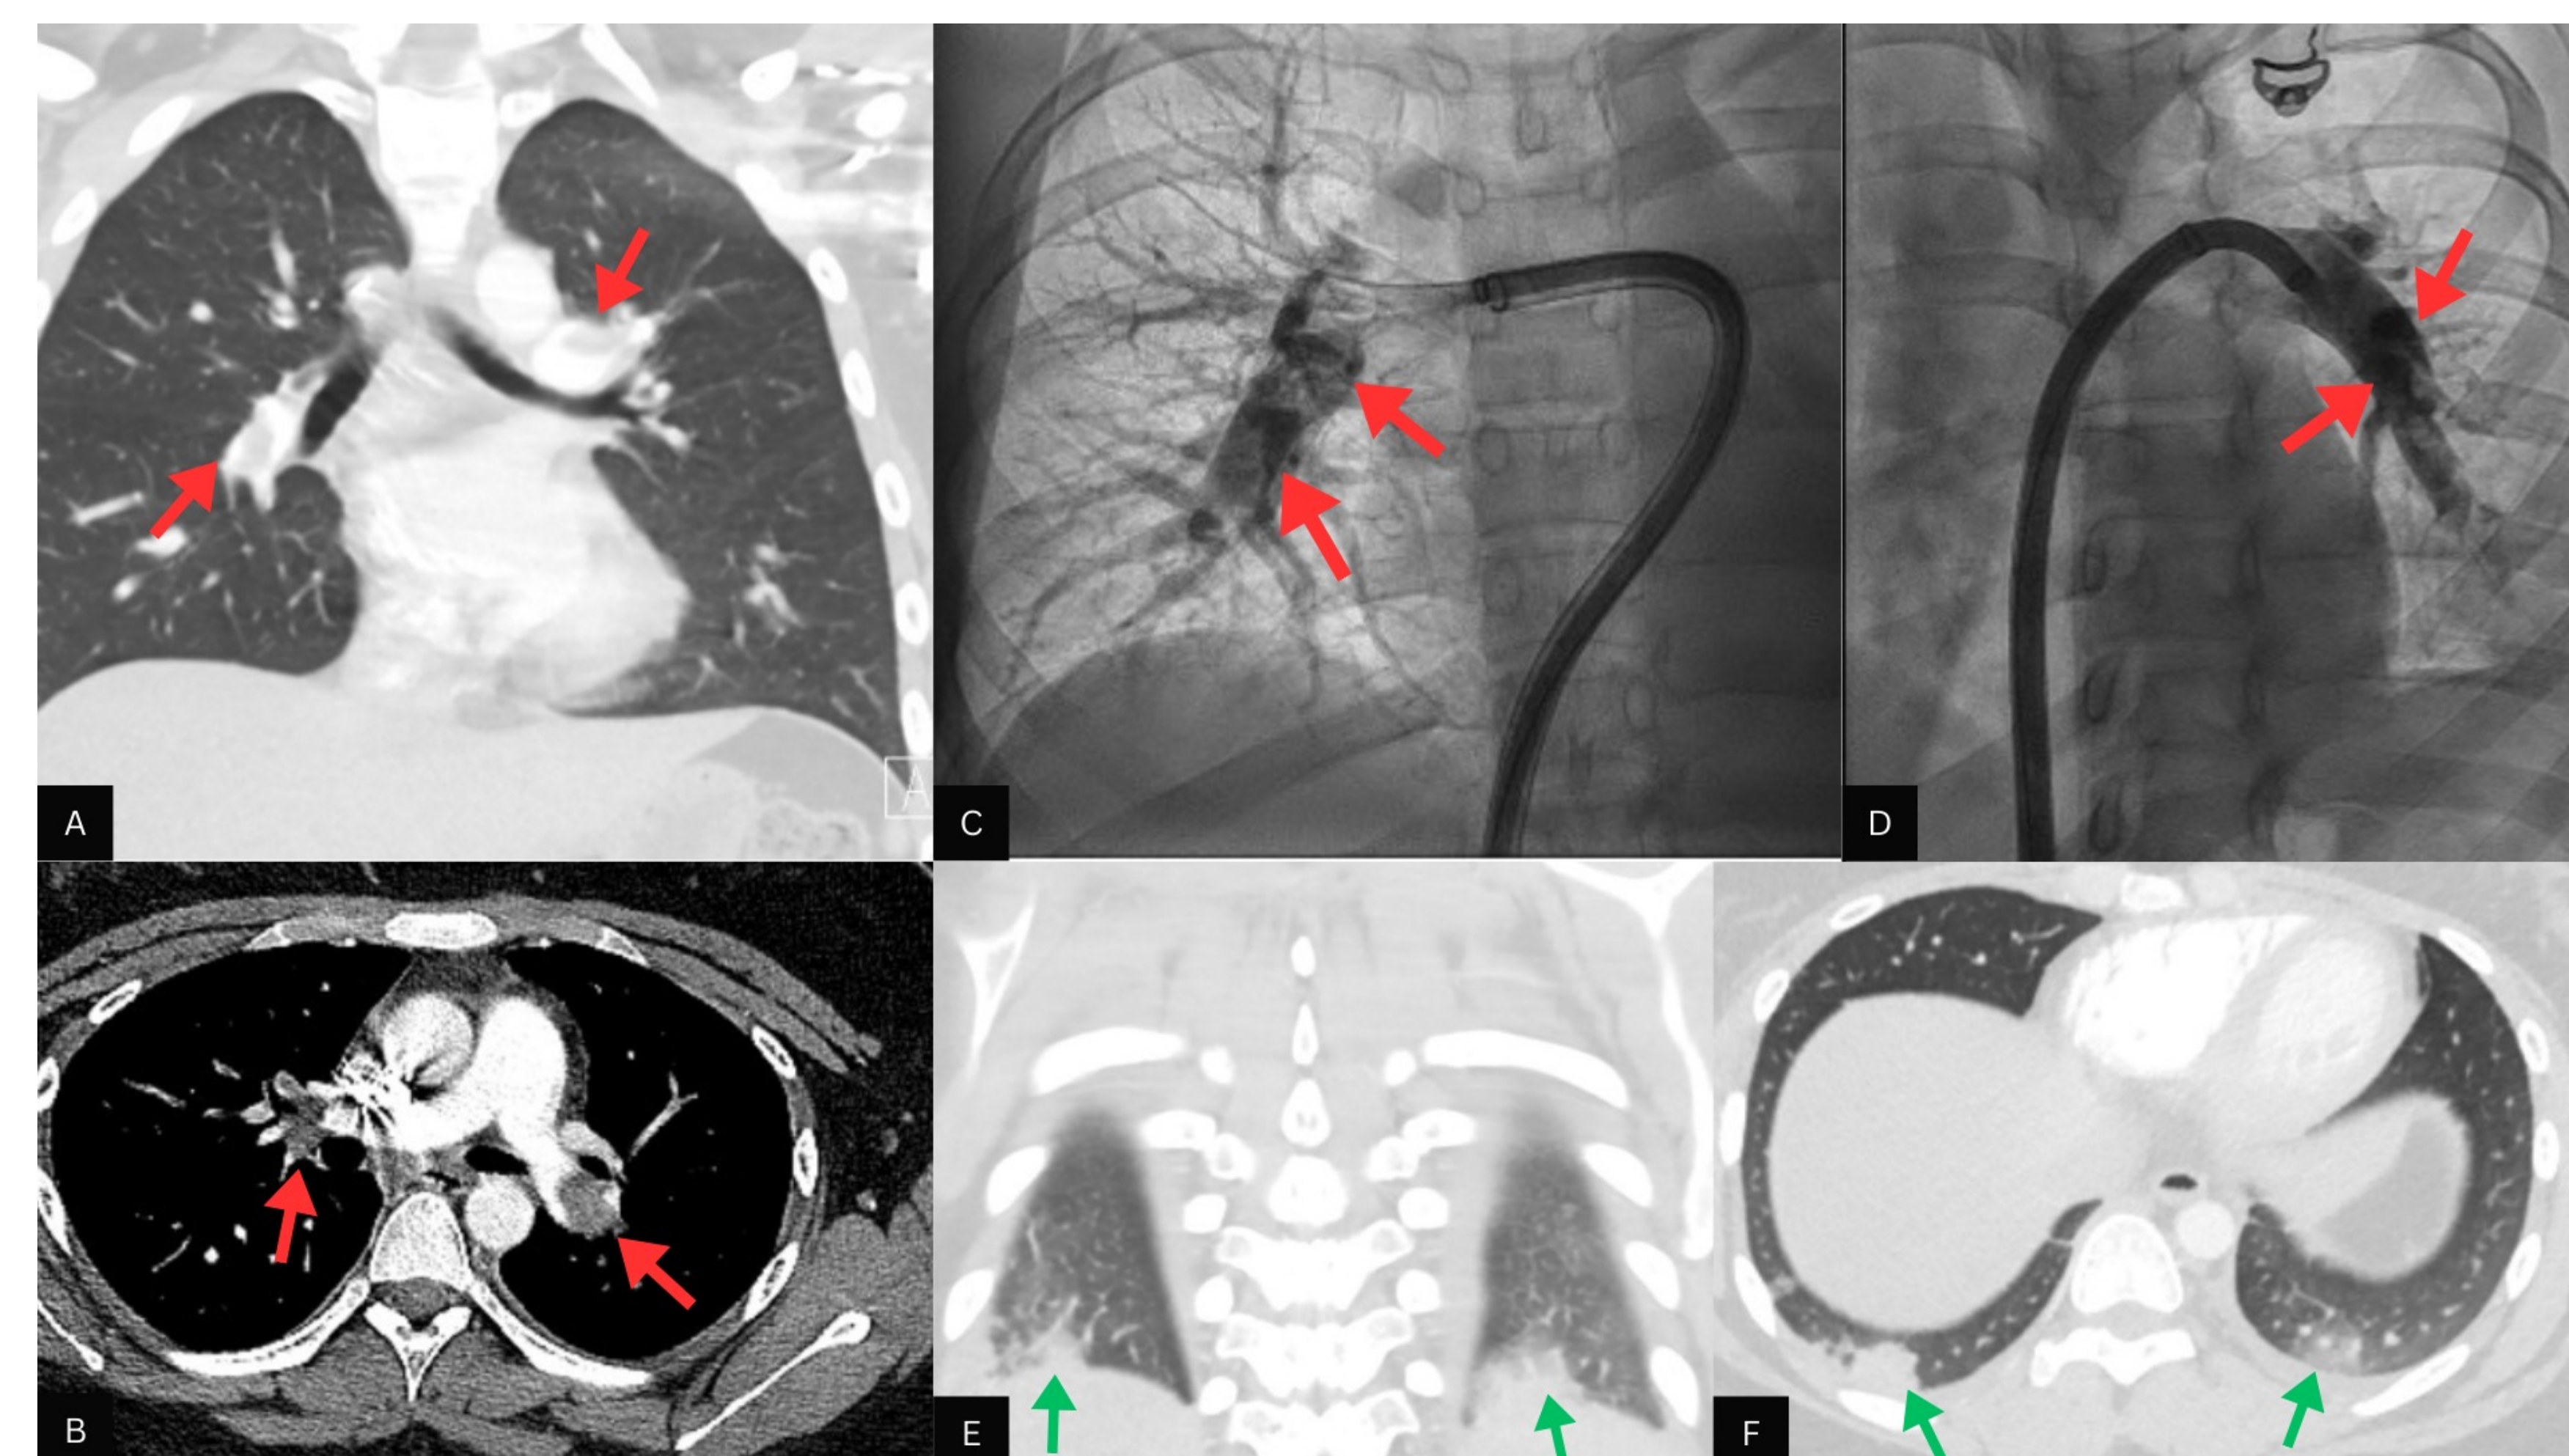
Computed Tomography Angiography (CTA) PE contrast protocol, Coronal (A) & Axial (B) cuts, with right (C) and left (D) pulmonary artery angiogram imaging demonstrating bilateral pulmonary embolisms (red arrows). Additionally, CTA PE contrast protocol imaging of bilateral lung base parenchymal infarctions (green arrows) in Coronal (E) and Axial (F) cuts.
